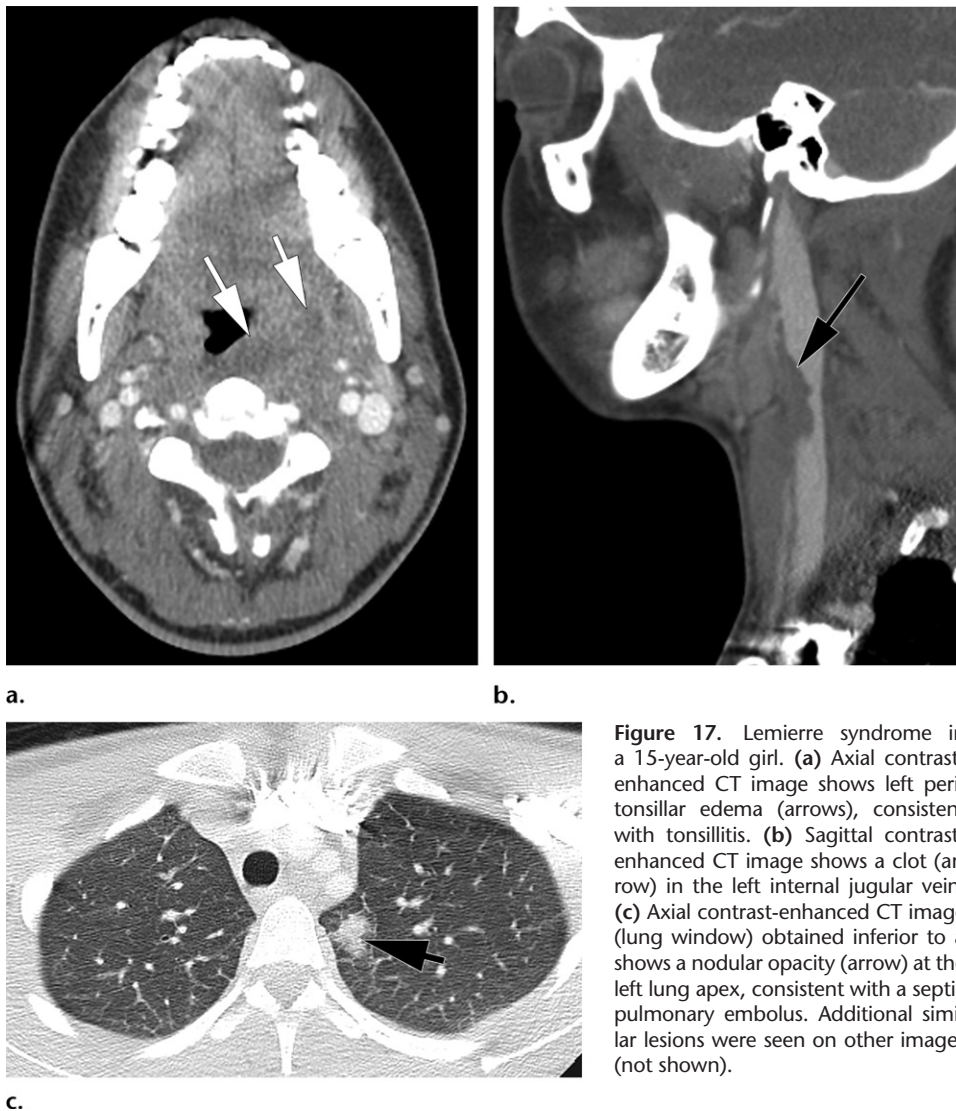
Lemierre syndrome in a 15-year-old girl. (a) Axial contrast-enhanced CT image shows left peritonsillar edema (arrows), consistent with tonsillitis. (b) Sagittal contrast-enhanced CT image shows a clot (arrow) in the left internal jugular vein. (c) Axial contrast-enhanced CT image (lung window) obtained inferior to a shows a nodular opacity (arrow) at the left lung apex, consistent with a septic pulmonary embolus. Additional similar lesions were seen on other images (not shown).
